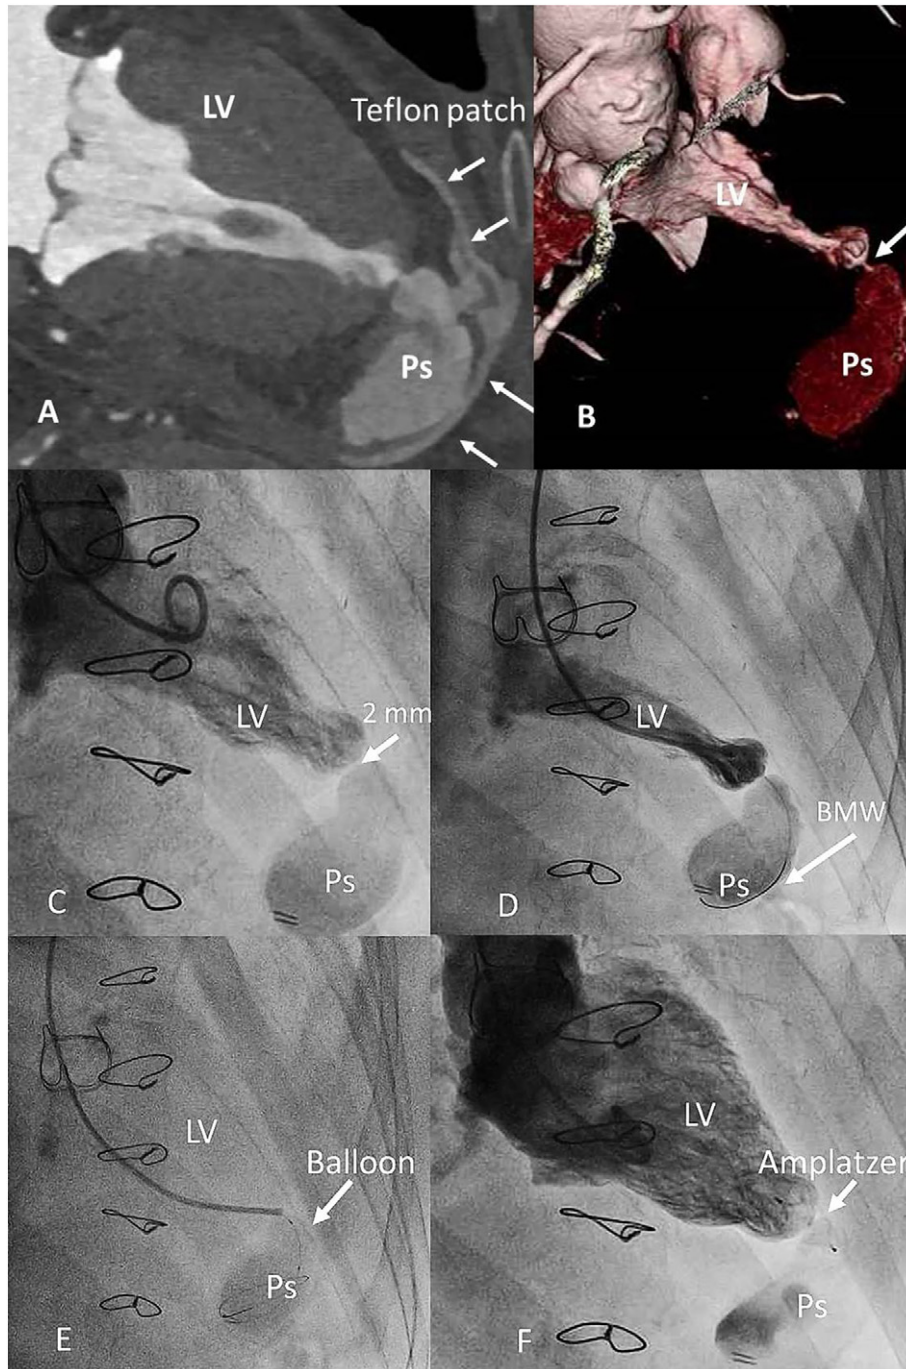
Panels A and B. Computed tomography (CT) shows left ventricle (LV), the pseudoaneurysm (Ps) surrounded by the Teflon patch completely detached from the LV, (white arrows), the thin neck of the Ps in 3 dimensional volume rendering CT (white arrow). Panel C. Left ventriculogram right oblique cranial view ($30^{\circ}/15^{\circ}$) demonstrated the thin Ps neck (2 mm). Panel D. Introduction of the balance middle weight (BMW) guidewire, curled up, inside the Ps cavity. Panel E. Crossing the Ps neck with the Sapphire II coronary dilatation balloon. Panel F. The final left ventriculogram showed the completely occlusion of the Ps sac with Amplatzer Vascular Plug 4 with a device diameter of 8 mm.
